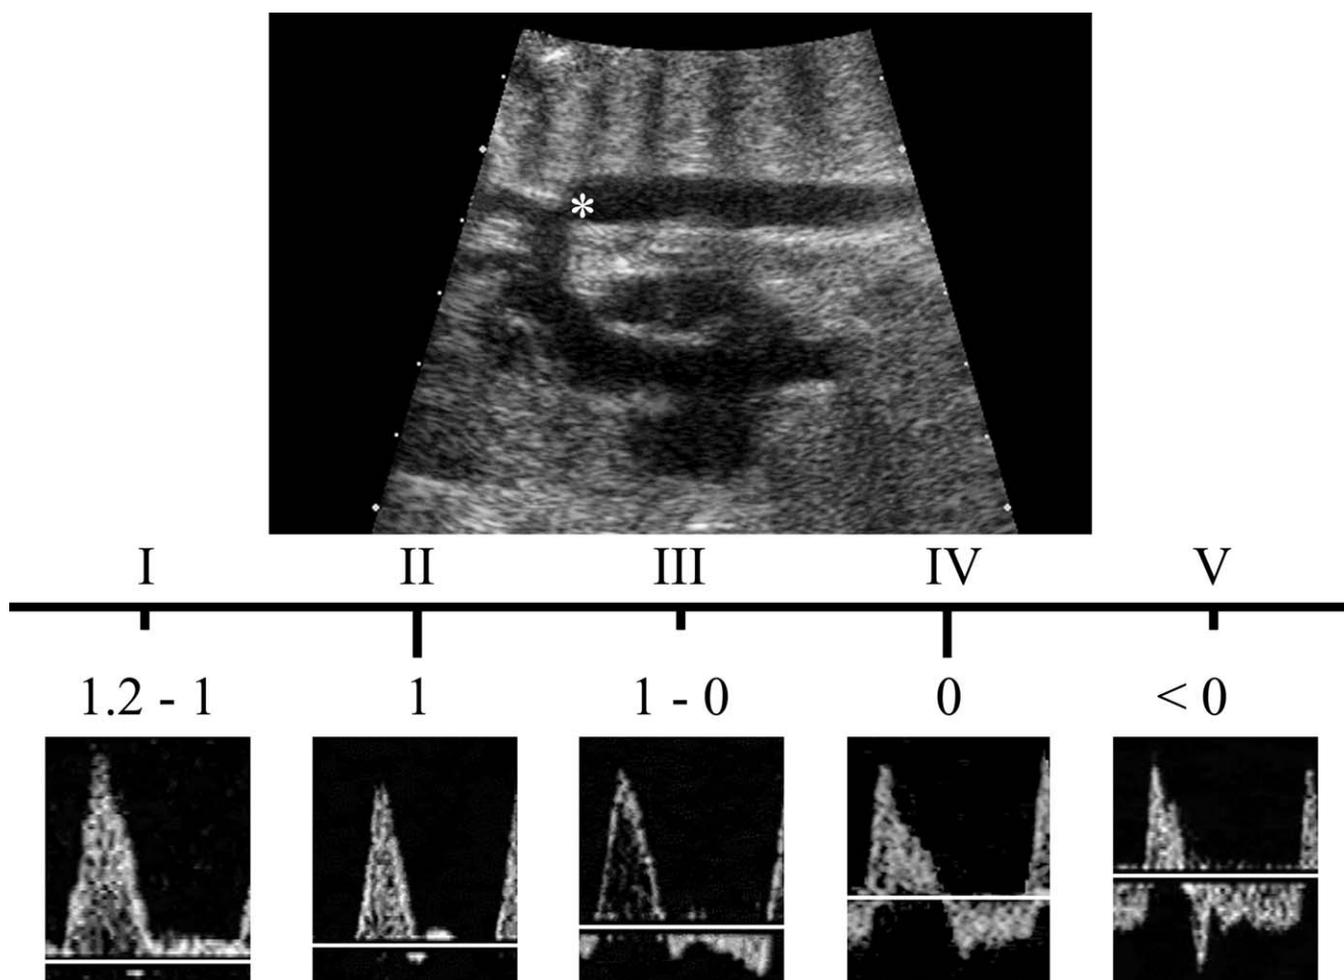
Top, Real-time echographic imaging of the aortic arch. The *asterisk* identifies the localization of the sample volume for Doppler interrogation in the isthmus. Bottom, Examples of isthmic Doppler blood flow velocity waveforms that were recorded in fetuses with various degrees of placental circulatory insufficiency. Above these tracings, 5 types (in roman numerals) with their corresponding IFI values (in Arabic numerals) relate to the increasing severity of the condition. *Type I*, Forward blood flow is observed in diastole; the IFI is > 1 but lower than normal. *Type II*, No isthmic diastolic velocities are recorded. *Type III*, Reverse diastolic blood flow is present, but with predominant antegrade blood flow in systole. *Type IV*, Antegrade systolic are equal to the retrograde diastolic velocities. *Type V*, The reverse diastolic blood flow is dominant and net blood flow through the isthmus is retrograde. Values of IFI are then negative, < 0 .
